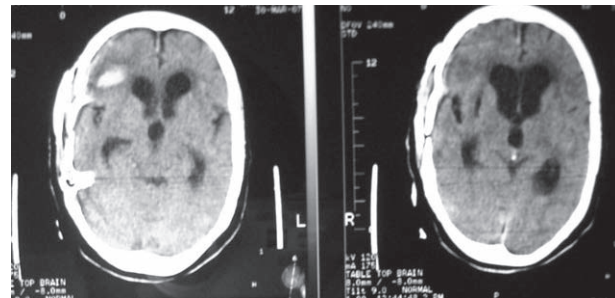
Repeat CT showing increased ventricular size and resolution of intraventricular blood following the blockade of external ventricular drain.
